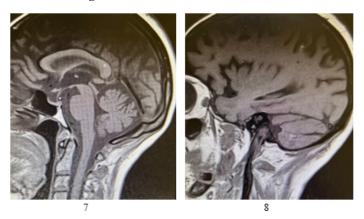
MRI brain December 2023.
